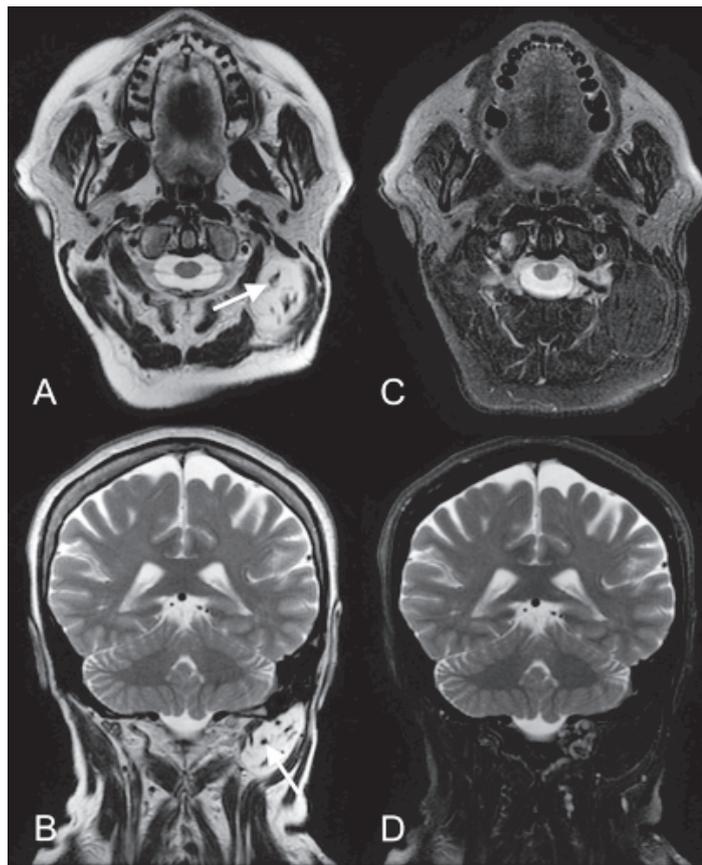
Unenhanced Fast Spin-Echo (FSE) MRI acquisitions – obtained using a 1.5 Tesla scanner. Figure 1A shows the presence of a sub-fascial oval-shaped mass, deep-seated, postero-inferior in left retromastoid region. On Fast Spin-Echo (FSE) T1 and T2-weighted images (Figures 1B and 1C), the lesion was located in the intermuscular space between splenius capitis and longissimus capitis muscles (white and black arrows).
